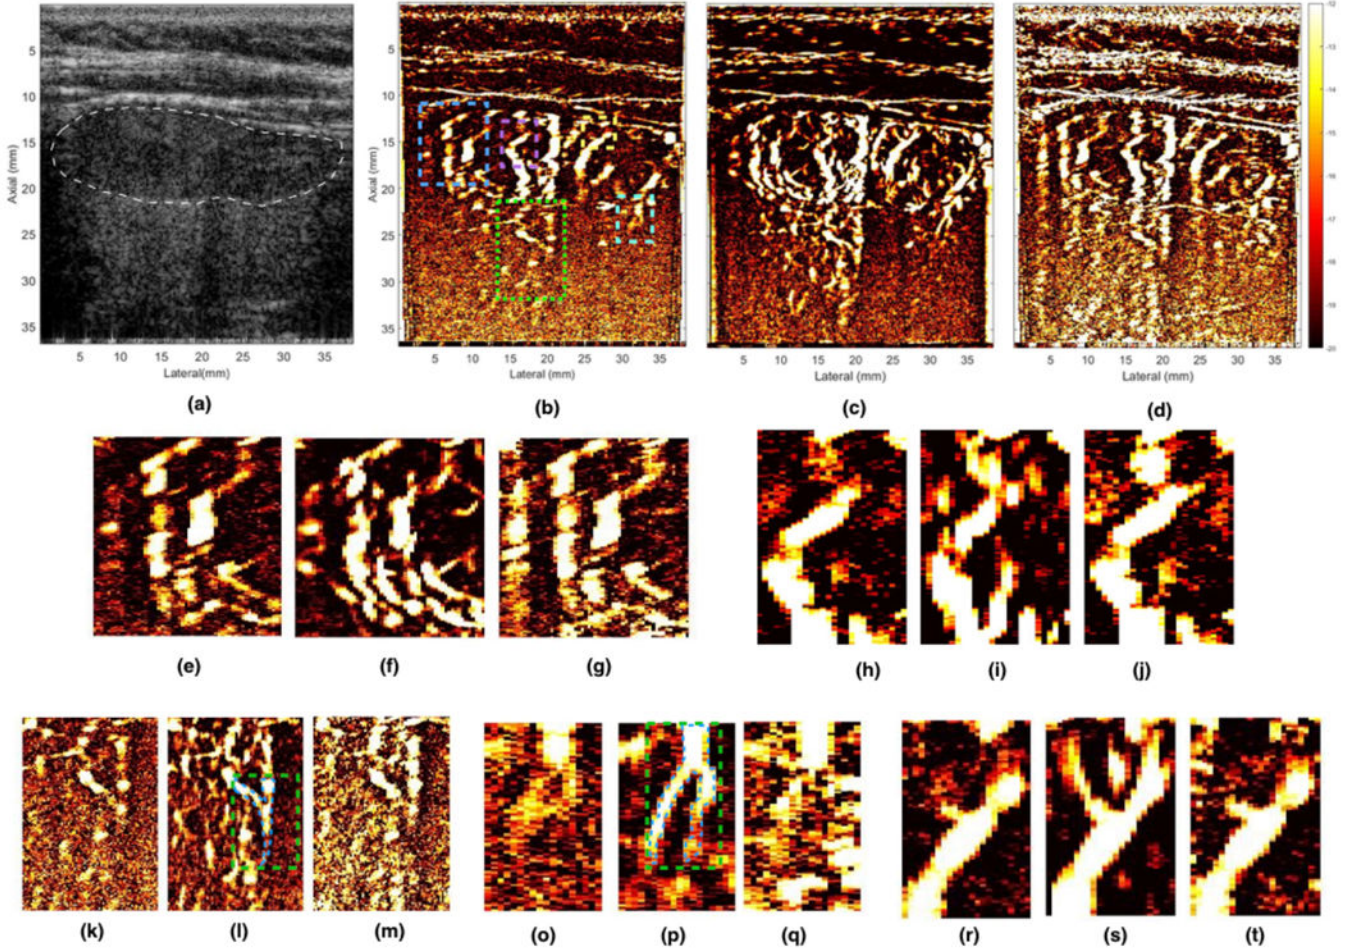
displays the representative in vivo B-mode and PD image of the thyroid nodule, obtained using SVD based clutter filtering. (a) displays the PW sonogram, (b, c) displays the PD image, pre- and post-motion correction, respectively, thresholded at the same SV threshold (420). (d) displays PD image corresponding to (b), but at a lower SV threshold (220), to allow increased contribution from blood signal, which may have been suppressed with clutter in (b). Figures (e, h, k, o, r) show zoomed insets obtained from (b). Figures (f, i, l, p, s) show zoomed insets obtained from (c). Figures (g, j, m, q, t) show zoomed insets obtained from (d). The ROI for the five zoomed insets have been outlined in the (b), where blue, magenta, yellow, green and cyan regions corresponds to (e-g), (h-j), (k-m), (o-q), and (r-t), respectively. The location of the nodule has been indicated in white in the sonogram (a). The CNR metric was calculated from the vessels indicated in green ROIs (l, p).
